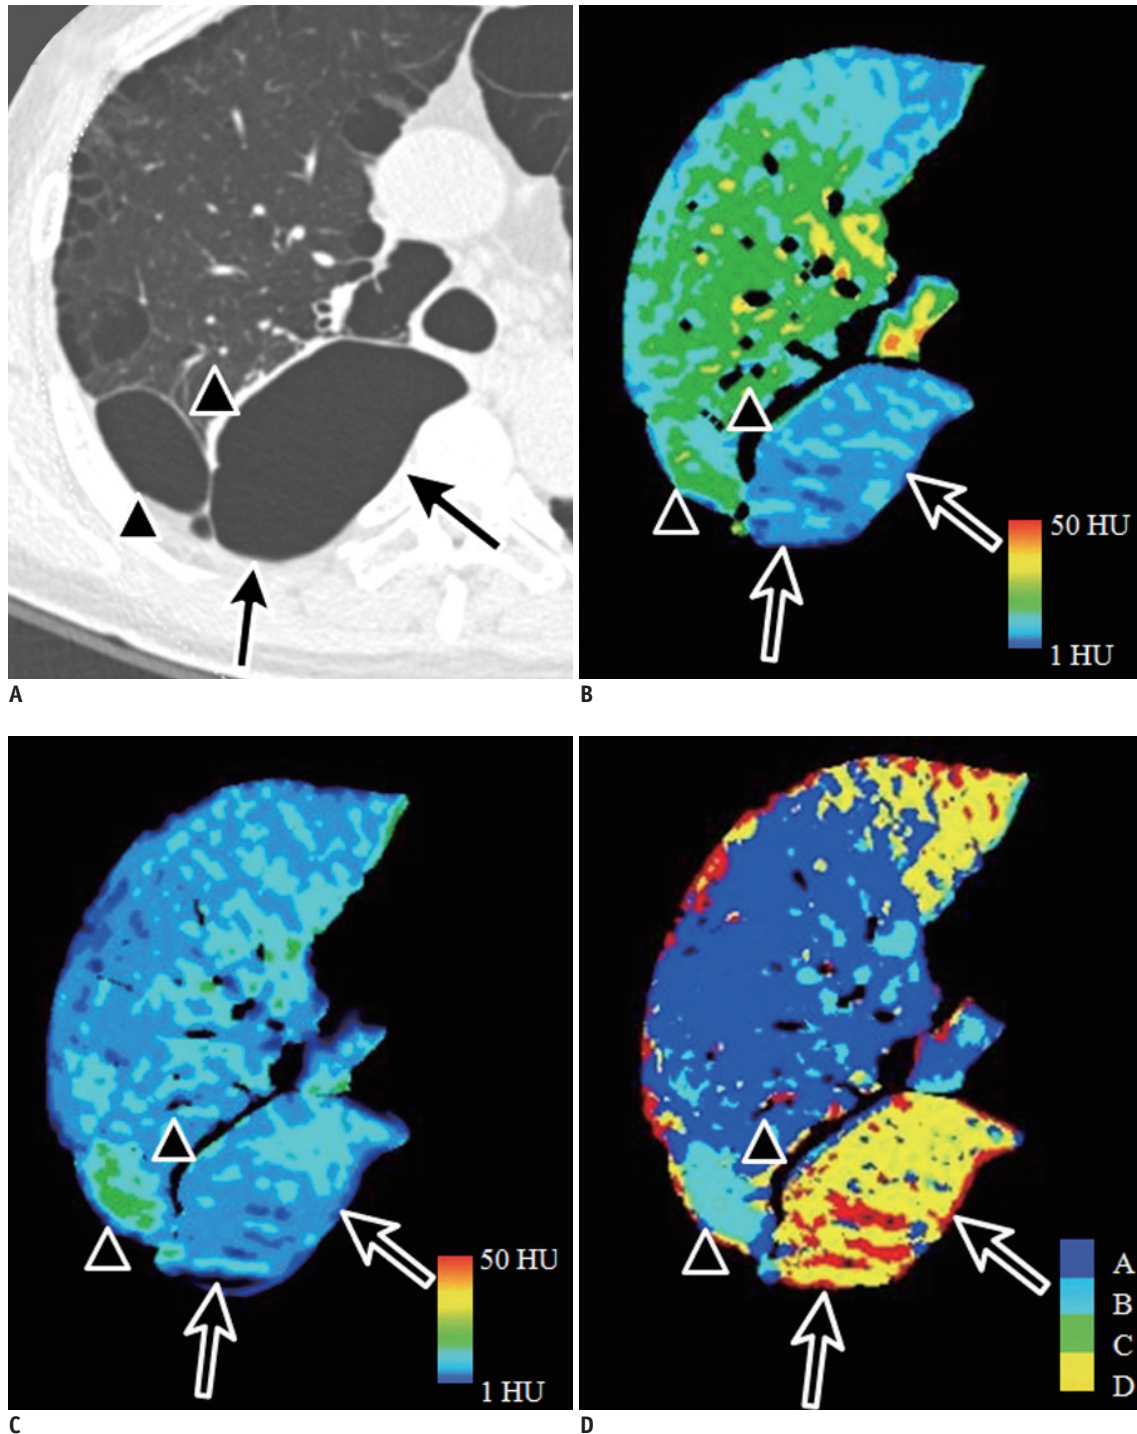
Representative image of patterns B and D for structural abnormalities in 72-year-old male with Gold stage II emphysema. Small subpleural bulla in right upper lobe on CT (A; arrowheads) shows high attenuation on wash-in (B) and wash-out xenon-enhanced images (C), which is compatible with pattern B shown in CAC map in sky blue (D). Large subpleural bulla in right lower lobe on CT (A; arrows) shows low attenuation on wash-in (B) and wash-out xenon-enhanced images (C). This ventilation pattern is in agreement with pattern D and is correctly visualized on CAC map in yellow (D). CAC = computer-aided classification
